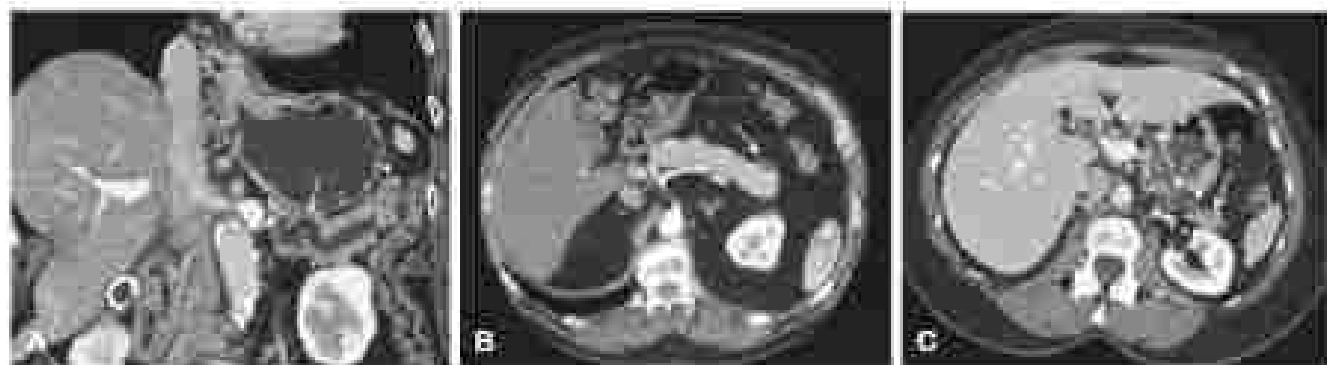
(A) Sagittal multidetector computed tomography image showing main duct intraductal papillary mucinous neoplasm with notable dilation (arrow) of the main pancreatic duct. (B) Axial multidetector computed tomography image showing a small cystic lesion in the pancreatic tail (arrow) consistent with branch duct intraductal papillary mucinous neoplasm. No dilation is observed in the main pancreatic duct. (C) Mixed-type intraductal papillary mucinous neoplasm on computed tomography scan. There is notable dilated dilation of the pancreatic duct in the head and body of the gland (arrowheads) and multiple small branch duct lesions throughout the body and tail (arrows).
